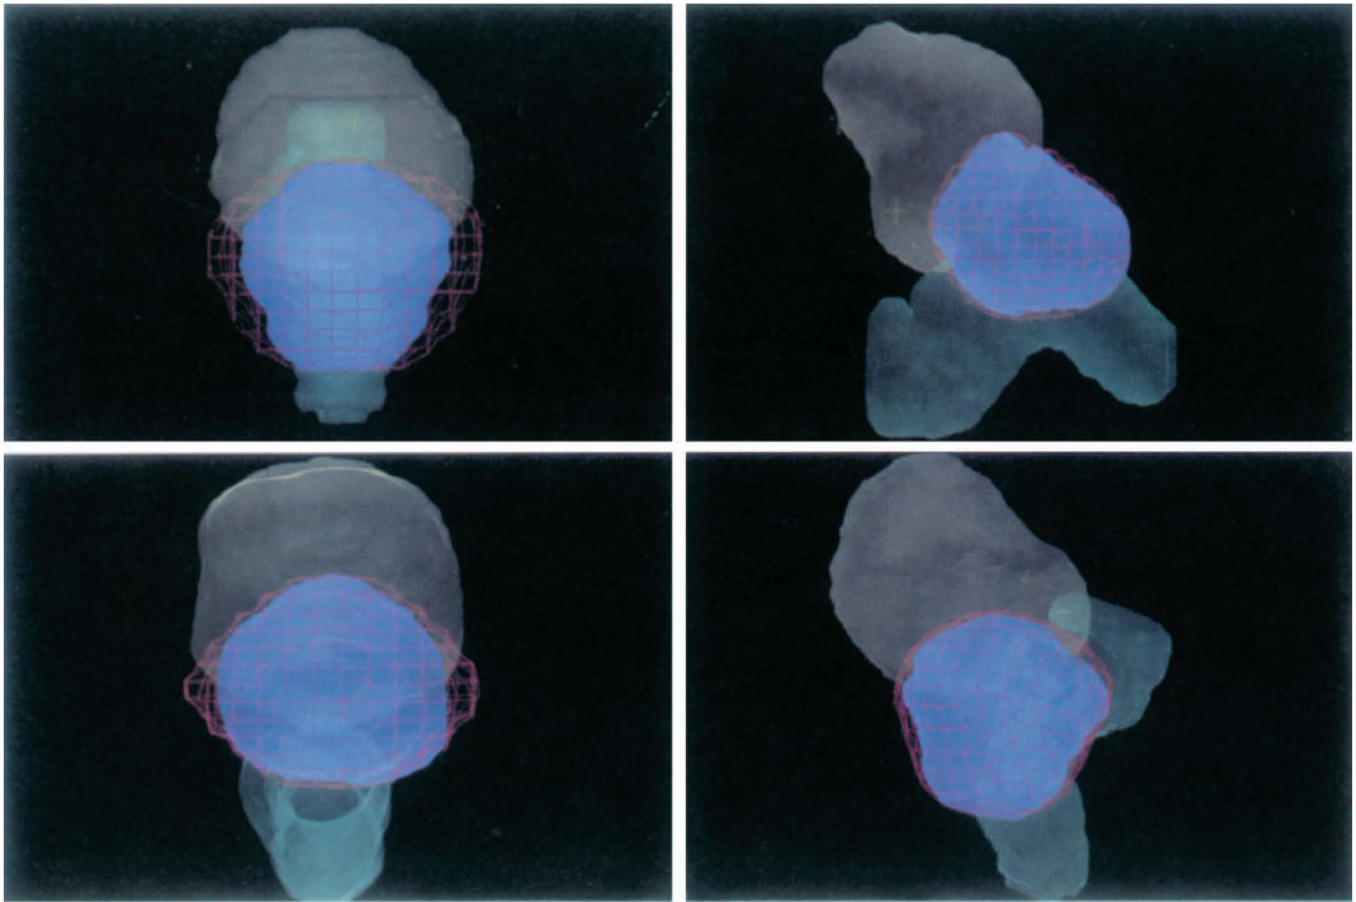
e. Anterior and right lateral field BEV DRR (Digitally Reconstructed Radiographs) display showing the prostate PTV, PRV for rectum and bladder, beam aperture (multi-leaf collimator), and fiducial cross hair grid.
